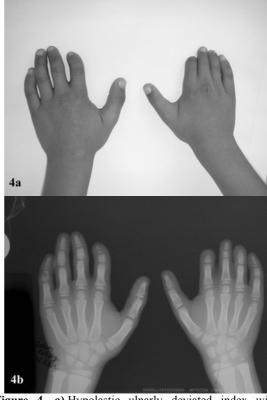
a).Hypolastic ulnarly deviated index with incomplete SD on left. b). Radiographs show agenesis of distal parts of right index. The middle phalanx of left index is in delta shaped causing ulnar deviation. Hypoplasia and cone epiphysis in the middle phalanges are also seen. There is a marked hypoplasia in the right fourth finger with a small ossicle as distal phalanx.
